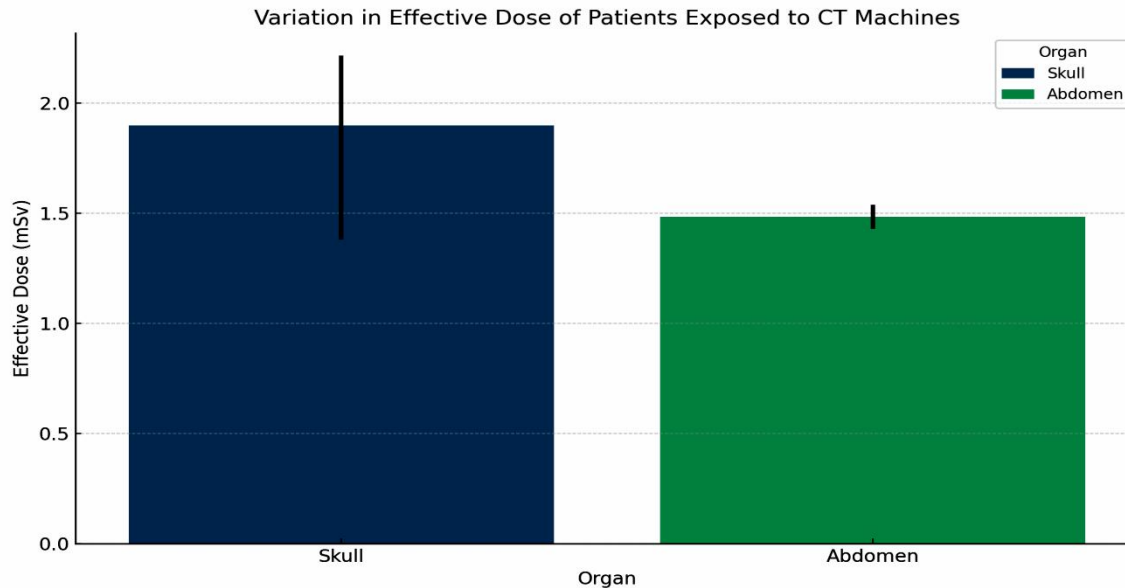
Effective dose of patients exposed to computed tomography machine
